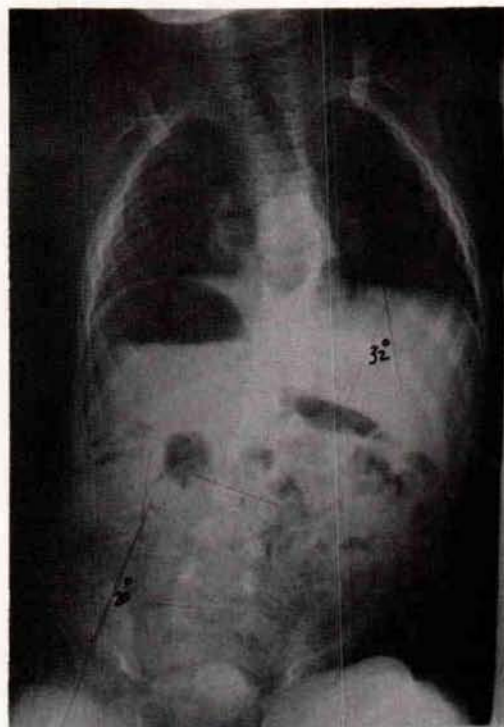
The A-P X-ray of a child with severe cerebral palsy.
